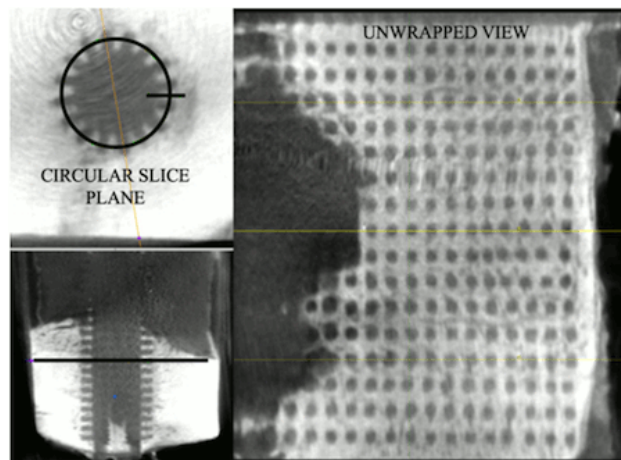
Cylindrical Slice CT, 12wk, 1000µm PEEK
